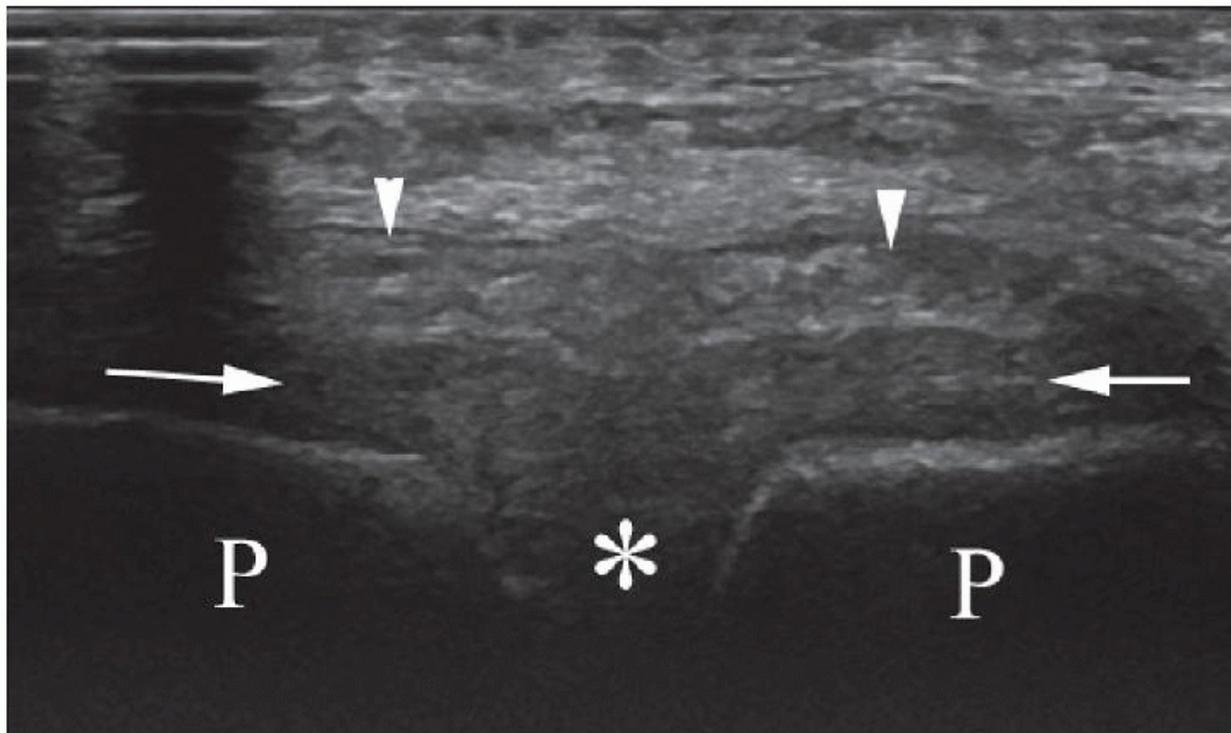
Normal pubic symphysis. Transverse sonogram shows pubic symphysis joint space and disc (asterisk), pubic bones (P), anterior capsule (arrows) and attachment of rectus abdominis muscles (arrowheads).
